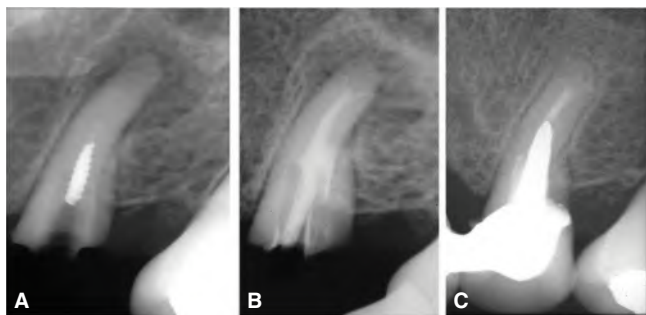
Resolution of a periradicular lesion. Long-term follow-up of nonsurgical endodontic retreatment in a maxillary second premolar of a 30-year-old female. Patient sought treatment after the prosthetic restoration on the tooth fractured. A. Preoperative radiograph showing a large periapical radiolucency associated with the tooth. Deficient endodontic treatment and a separated screw post is observed. B. Immediate postoperative radiograph. Complex apical anatomy is demonstrated by sealer extrusion (arrows). C. 11-year follow-up radiograph showing resolution of the periapical radiolucency. The tooth is asymptomatic and serves as abutment for fixed prosthesis.
